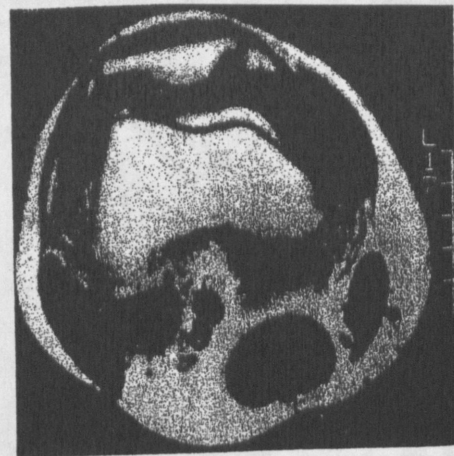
Axial T1-weighted image (400/12) of the knee of a patient with a joint effusion. Notice that the cartilage of the lateral patellar facet shows a trilaminar appearance of superficial hyperintense signal, intermediate hypointense signal, and deep hyperintense signal. Frequency encoding is from top to bottom, and phase encoding is from left to right.
